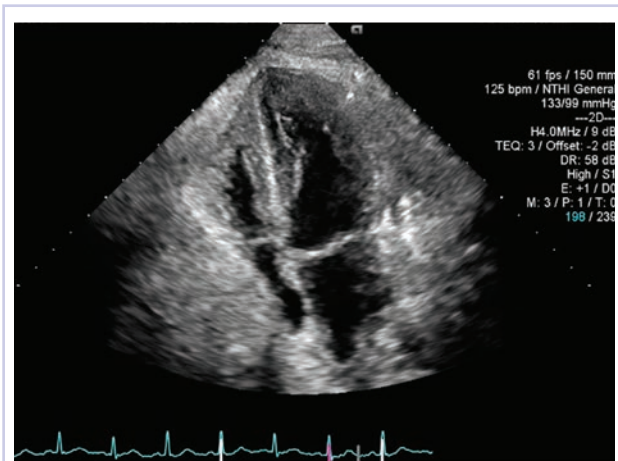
Echocardiogram showing extrinsic compression of the heart resulting in tamponade physiology.
